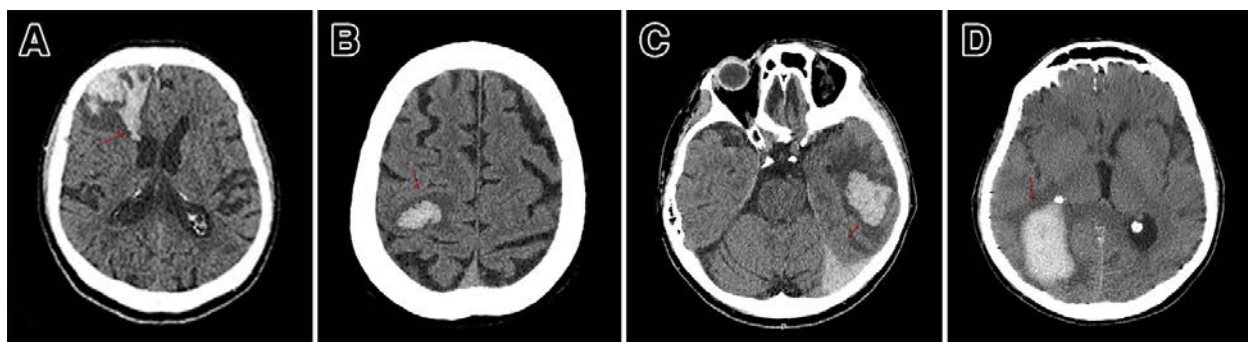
Lobar types of intracerebral hemorrhages (red arrows) with various locations in axial computed tomography scans: frontal (A), parietal (B), temporal (C), and temporooccipital (D).
